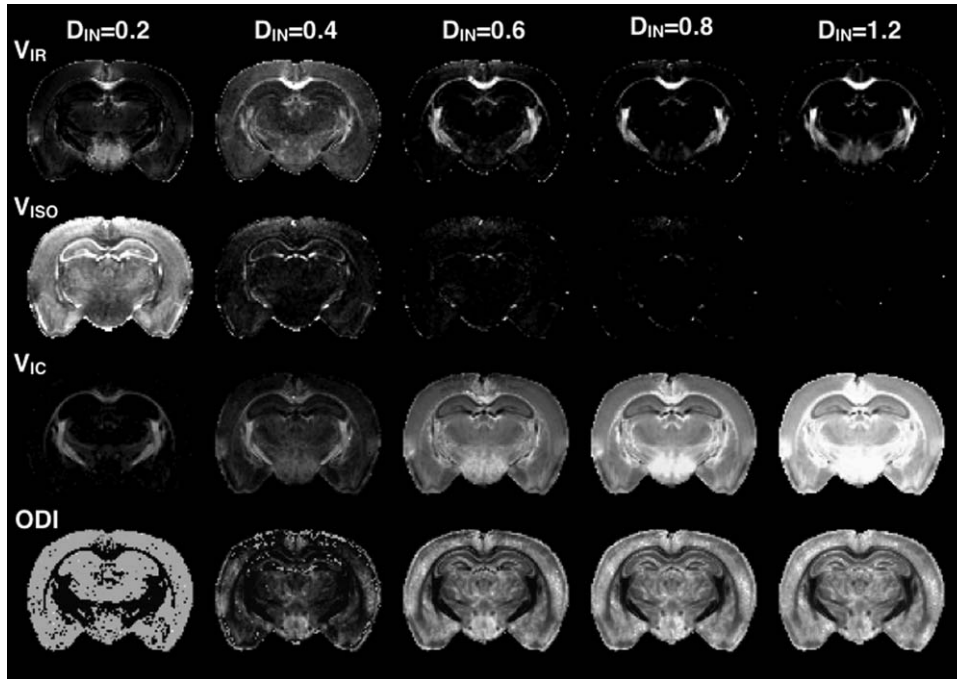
Effects of the fixed parameter D_{IN} on the NODDI metrics maps of V_{IR} , V_{ISO} , V_{IC} , and ODI are shown by representative slices from metric maps generated for the same DWI dataset following NODDI modeling with different values for D_{IN} .
